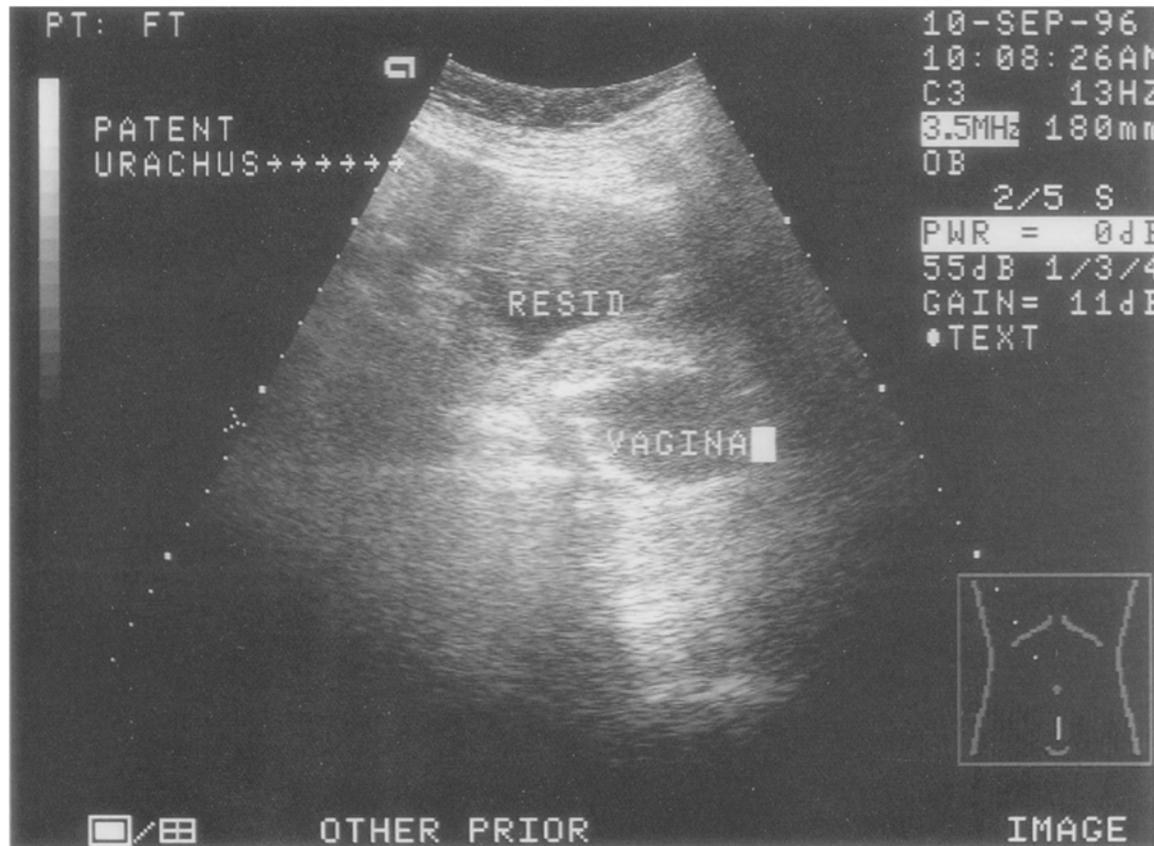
Transabdominal ultrasound picture of bladder with postvoid residual. A patent urachus is visible in the upper left-hand corner of the ultrasound image. A water-filled condom is in the vagina.
